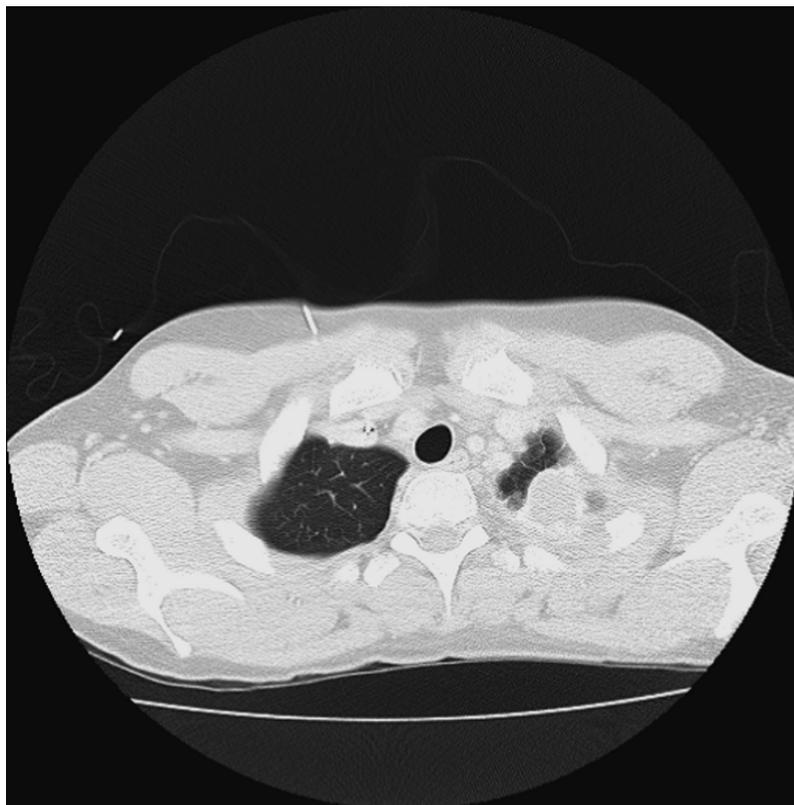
CT scan of an apical metastasis that was only resectable after radiation therapy.
